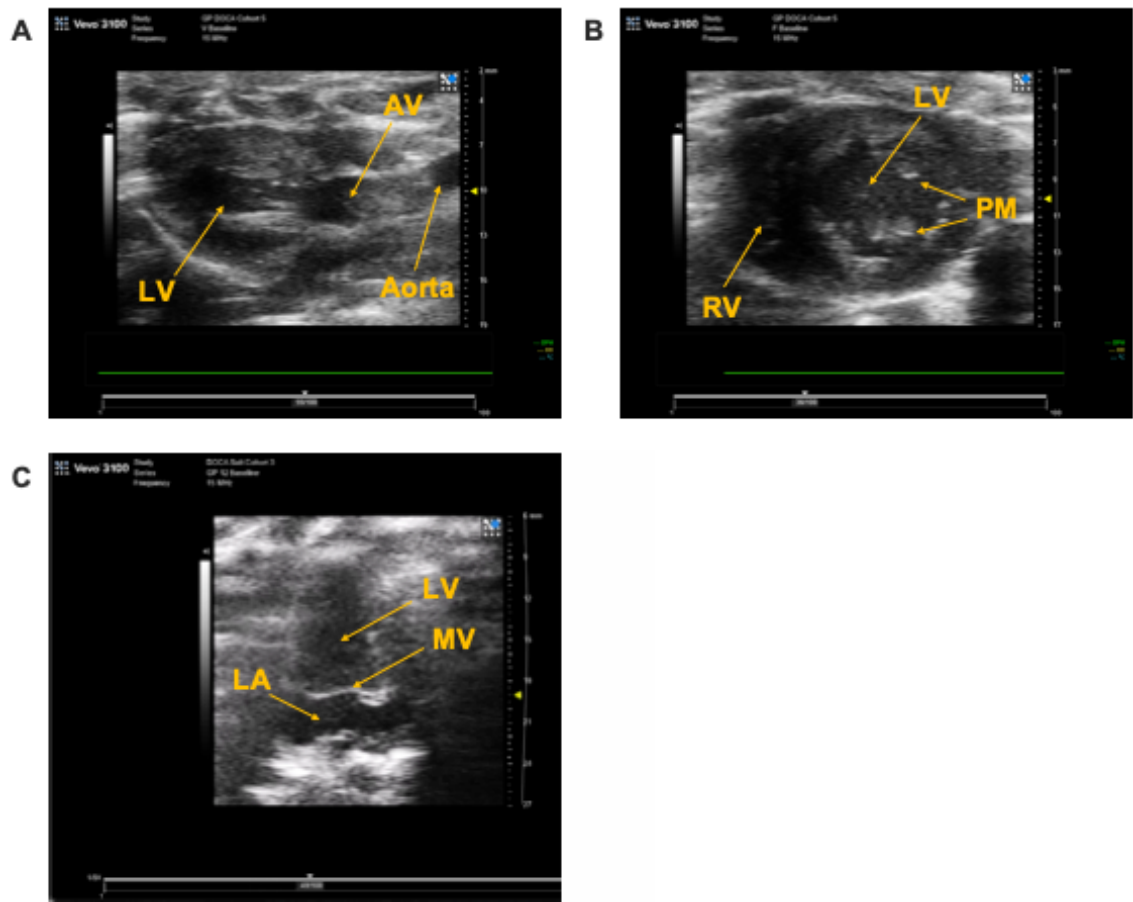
Views used in collection of cardiac ultrasound data
